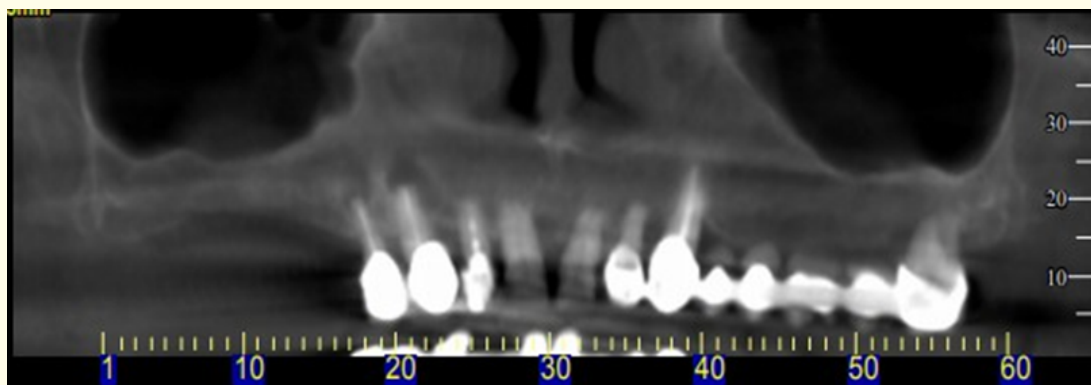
Pre-op cone beam computed tomography (CBCT) of the upper jaw.
